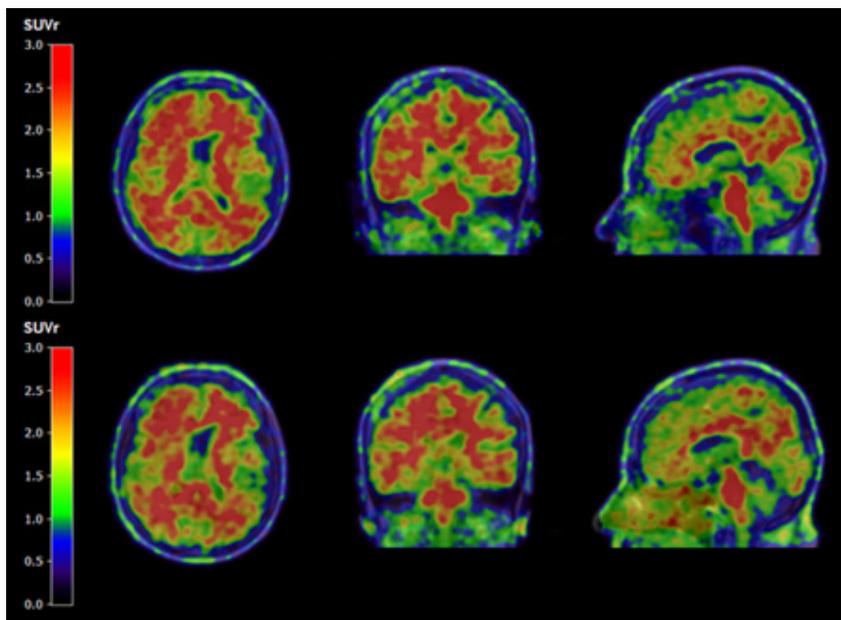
Example of corresponding FMM images that were rated as amyloid-positive on both PET/CT (top row) and PET/MR (bottom row). Data from this subject are representative for the entire sample.
